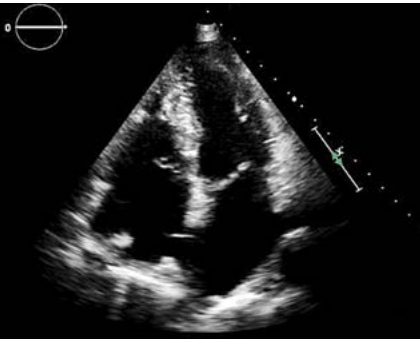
Apical 4-chamber view demonstrating a right atrial mass
